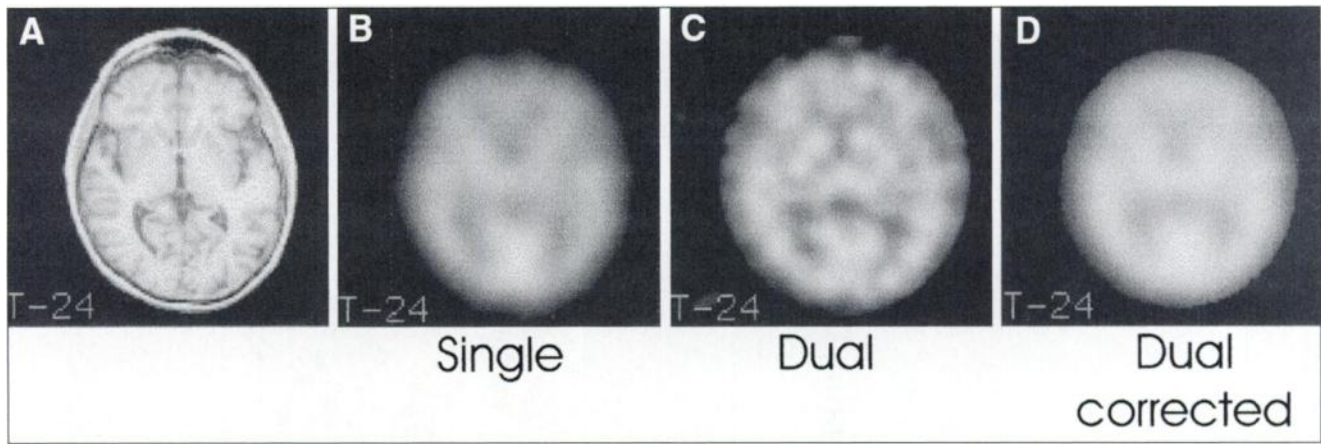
Effects on image quality of smoothing dual-head images (C, nonsmoothed, and D, smoothed) to match single-head image (B). Images have been coregistered to baseline MR image (A). Images are from healthy volunteer who served as baseline for templates.
